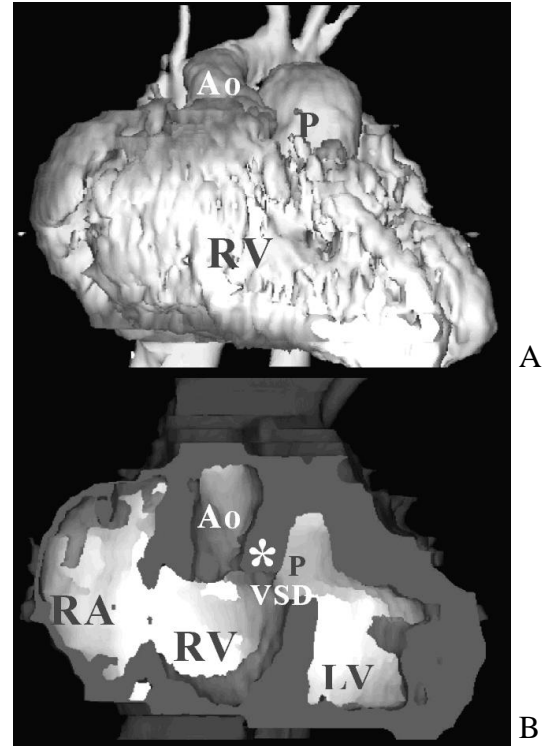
Sub-pulmonary type VSD of DORV. (A) 3D CTA revealed both PT & Ao arose from the RV with rather parallel relationship ( $130^{\circ}$ ). (B) 3D inner cardiac view demonstrated the location of the VSD just under the opening of PT. But,, overriding of the PT to LV was noted. The conus septum (\*) also ran in sagittal plane. Ao=aorta; LV=left ventricle; PT=pulmonary trunk; RA=right atrium; RV=right ventricle; VSD=ventricular septum
